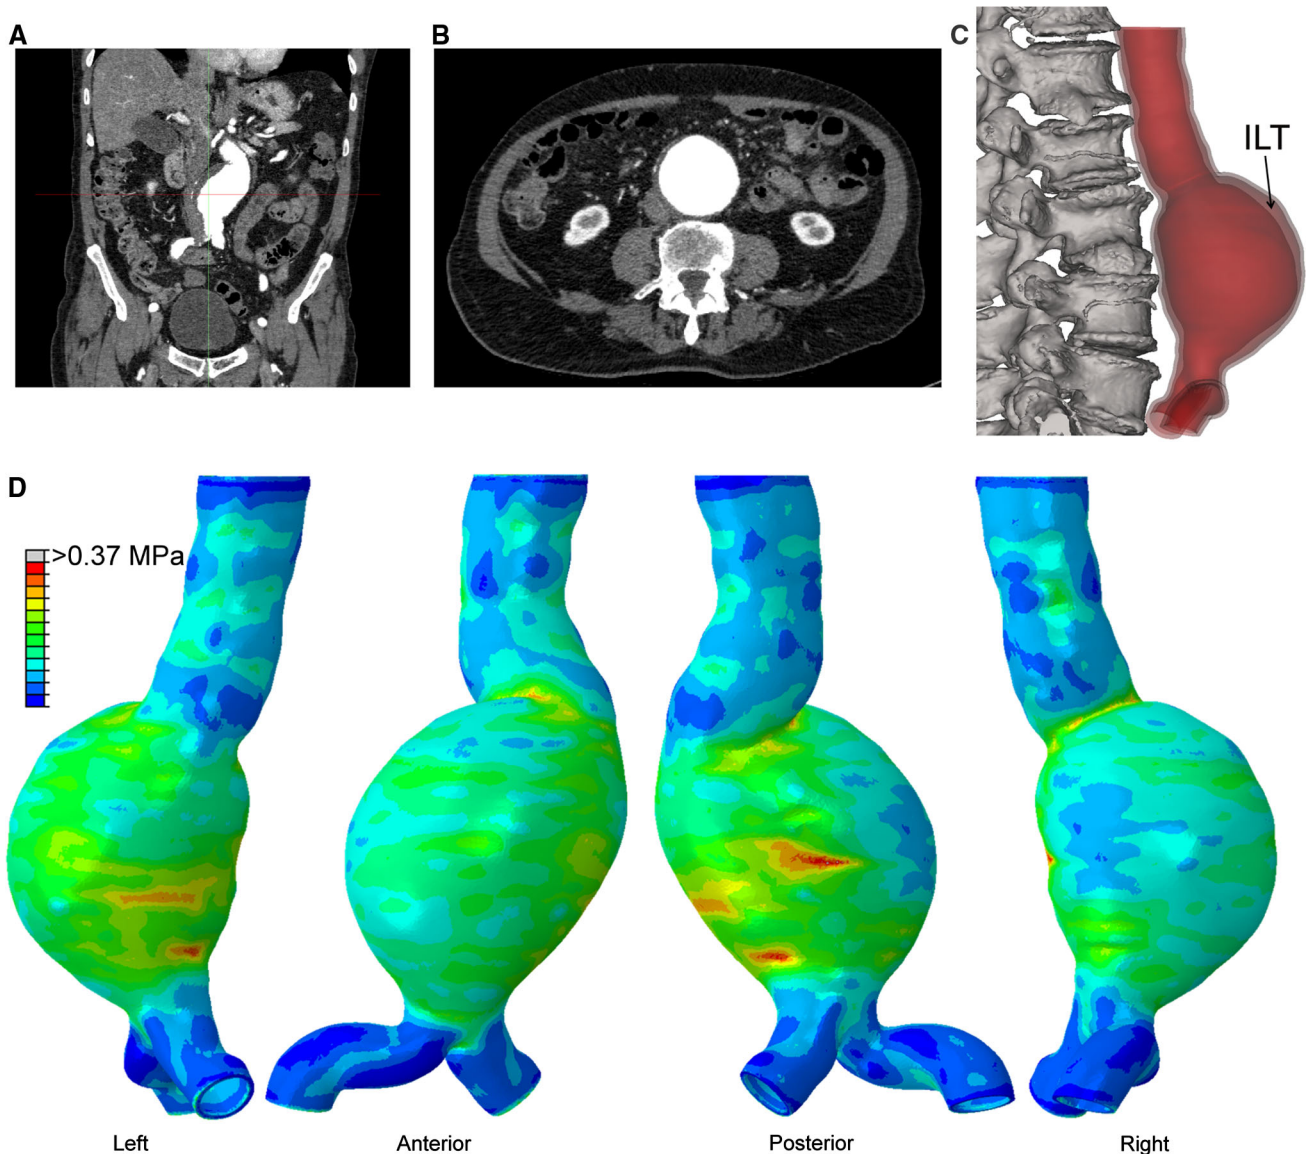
Baseline contrast-enhanced CT scan; coronal (A) and axial view (B) showing 6.0 cm AAA. C 3D reconstruction with the wall transparent to reveal the modest amount of ILT present. D The computed von Mises wall stress distributions at peak systolic
